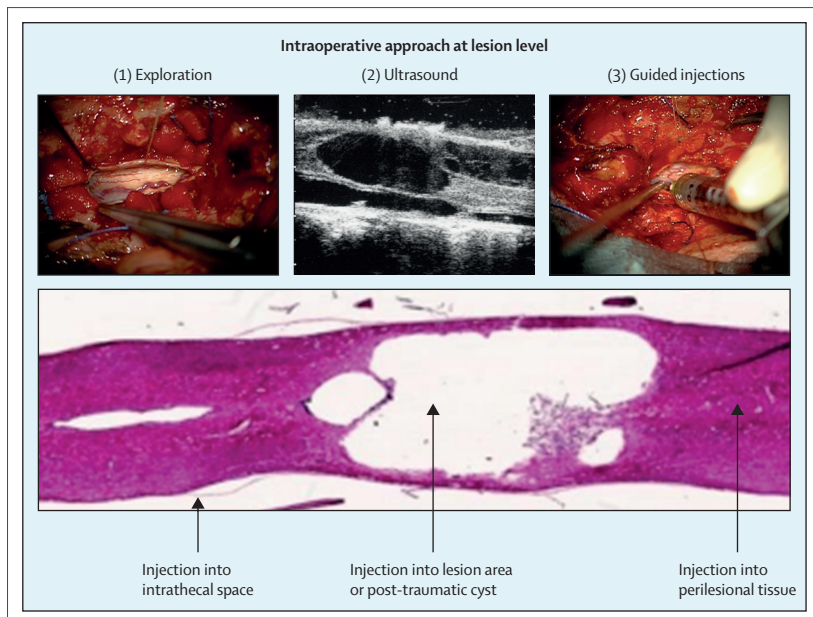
Intraoperative photos showing ultrasound-guided injections into the injured spinal cord (top), and areas suitable for intraspinal injections (bottom)
